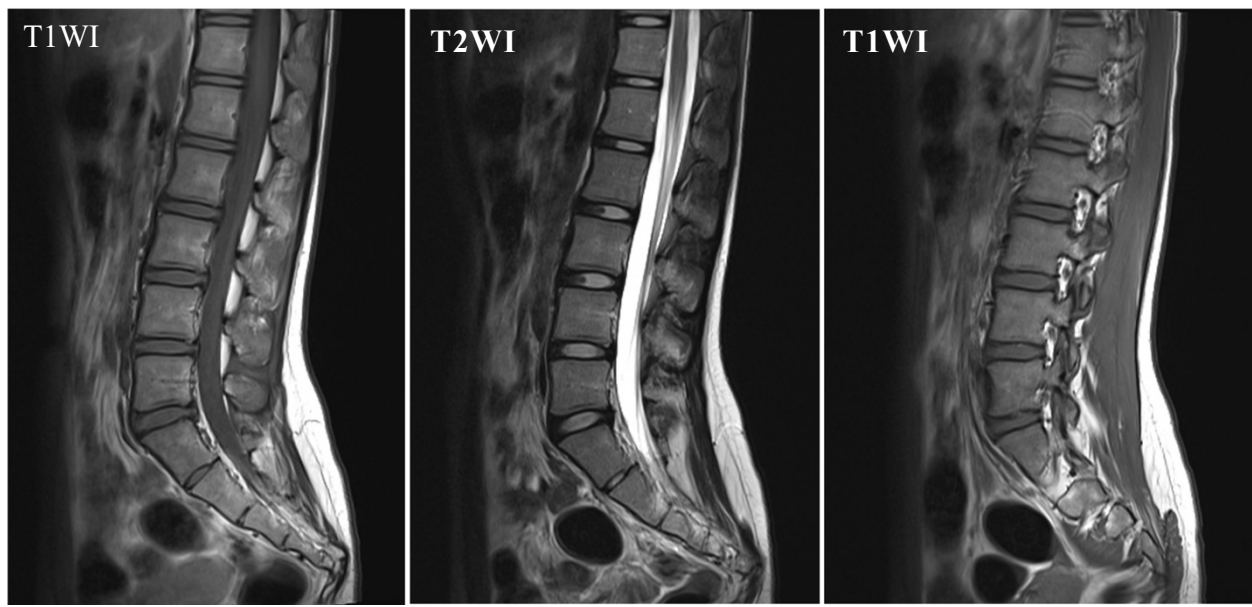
Magnetic resonance imaging examination of the lumbar spine [49]
